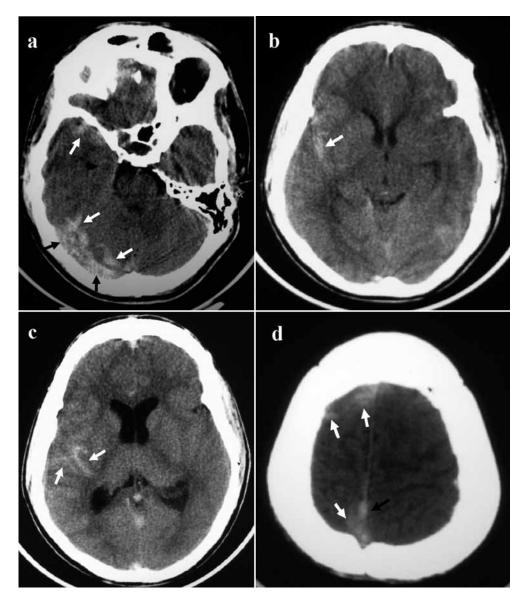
Axial computed tomography images without contrast (a-d) show hyperdense acute subarachnoid hemorrhage in the right supratentorial area, sylvian fissure, anteroinferior temporal, frontal and insular sulci (white arrows), and hyperdense right transverse sinus and superior sagittal sinus representing acute thrombosis (black arrows).
